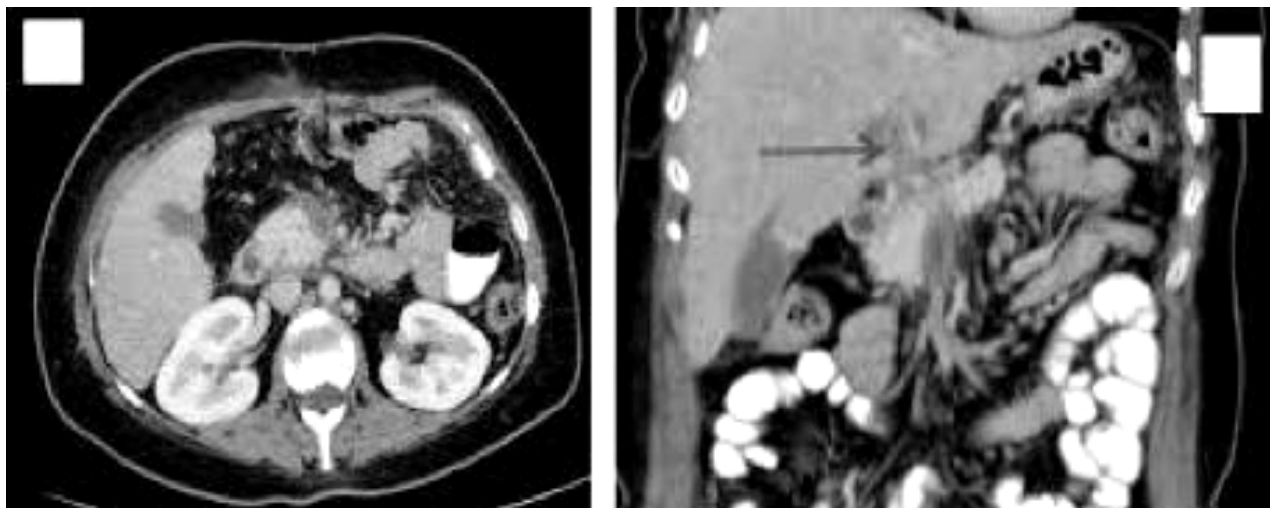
CT-angiography of mesenteric thrombosis in patient K., 58 y.o.
